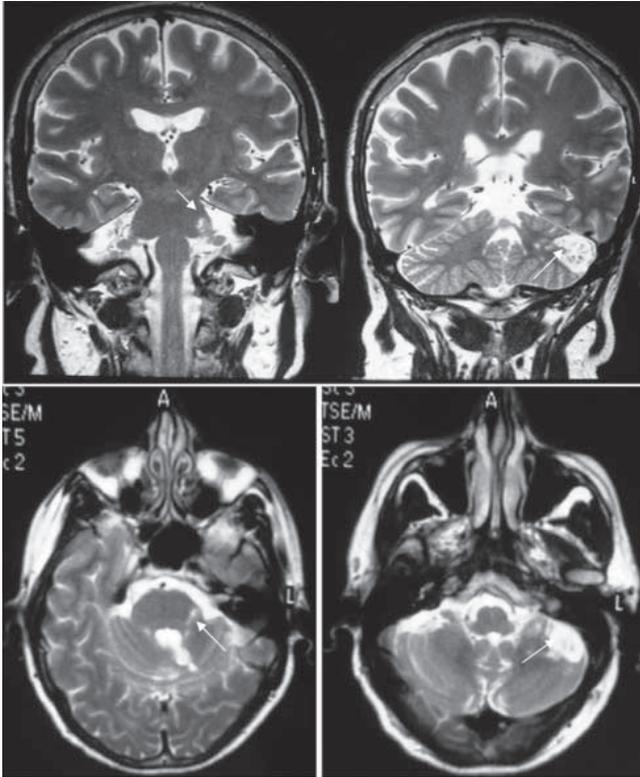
Axial and coronal T2 MRI images showing left partial AICA infarction (arrow).
